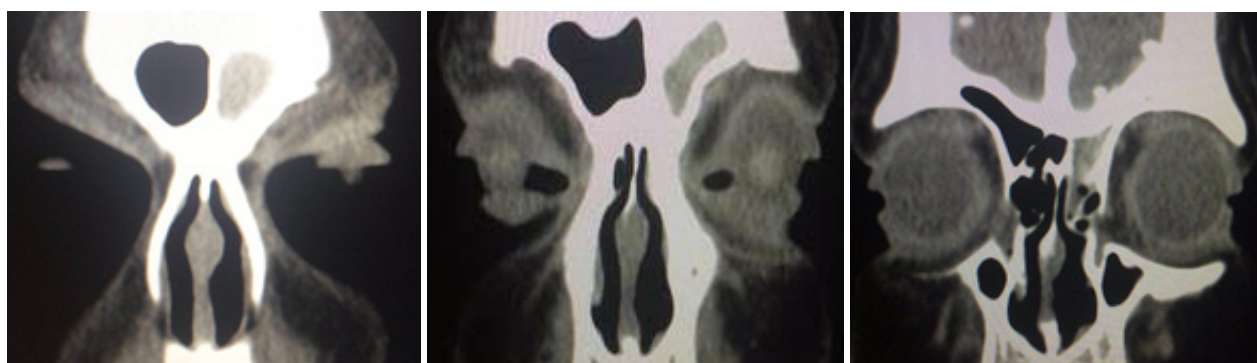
Coronal views of Computed tomographic scans of the paranasal sinuses showing heterogeneous opacity with microcalcification involving Left frontal sinus
